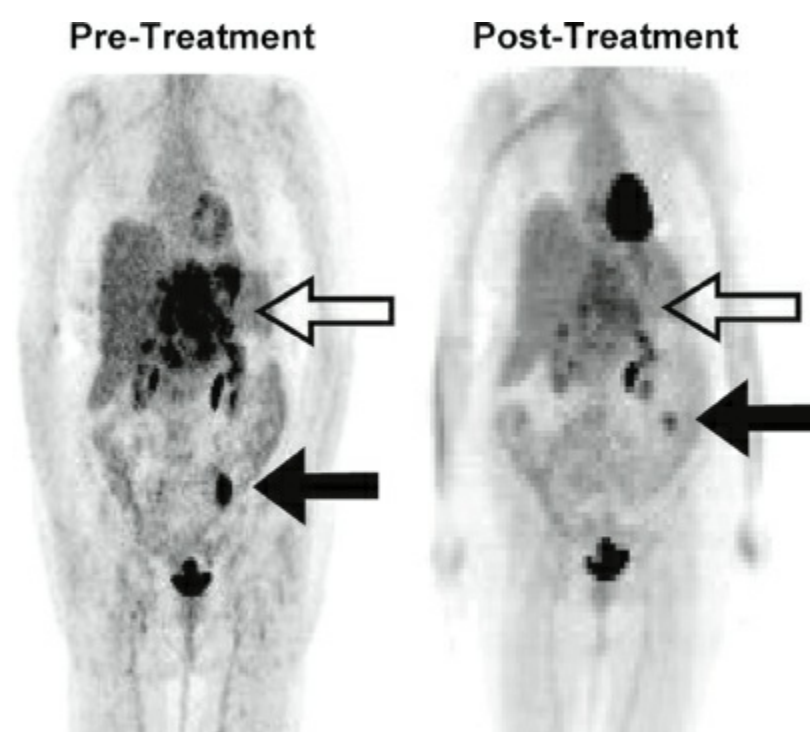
¹⁸FDG-PET scan showing response of metastatic GIST to imatinib mesylate. This patient presented with primary disease in the small bowel and synchronous metastatic disease in the liver. The scan at presentation (left) compared to the one obtained after 3 weeks of therapy (right) shows decrease in size of tumors and decreased ¹⁸FDG uptake in both the small bowel and liver tumors consistent with a good response to imatinib. The patient eventually went on to complete surgical resection. (From Gold JS, Dematteo RP. Combined surgical and molecular therapy: the gastrointestinal stromal tumor model. *Ann Surg* 2006; 244(2):176–184.)
